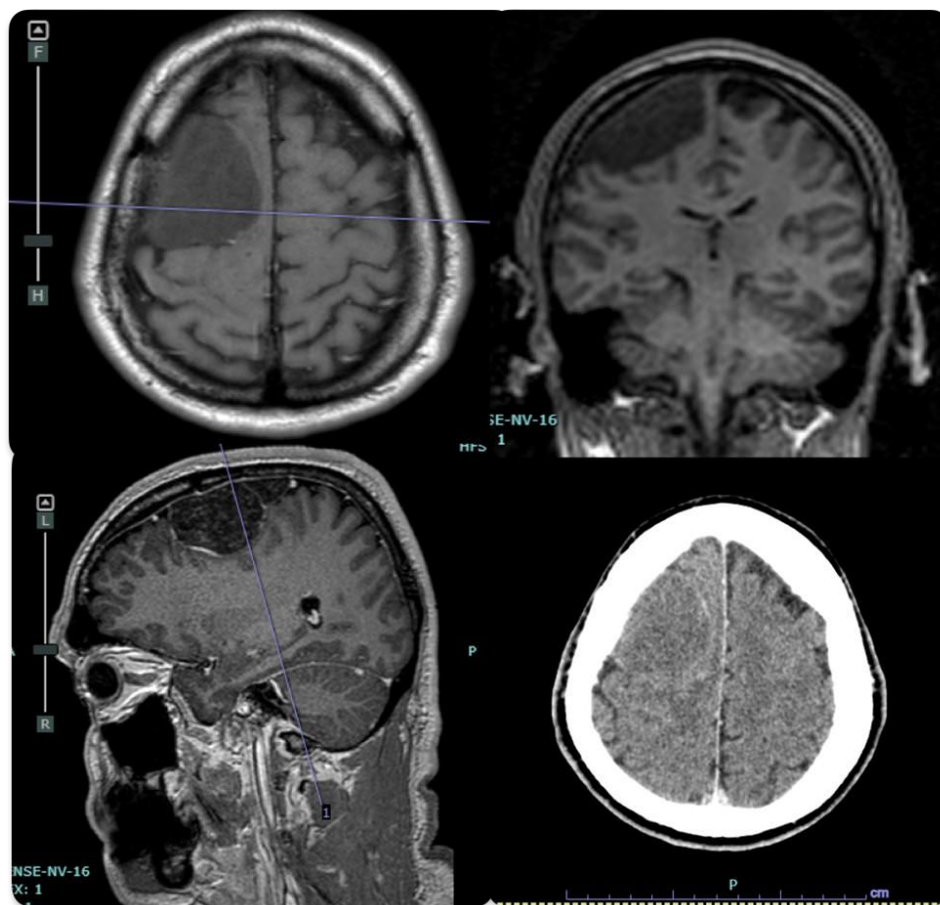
Preoperative MRI and CT scan views show: A well-defined, extra-axial, dural-based mass located in the right convexity region. On axial head CT finding of a isodense extra-axial lesion along the right convexity, associated focal calvarial hyperostosis.
